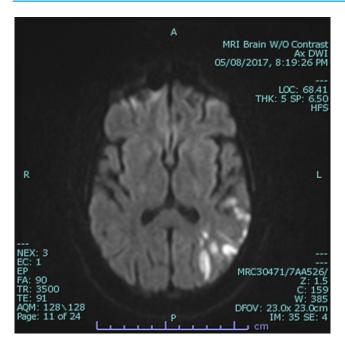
Subacute left parasagittal watershed infarct. MRI, magnetic resonance imaging.
